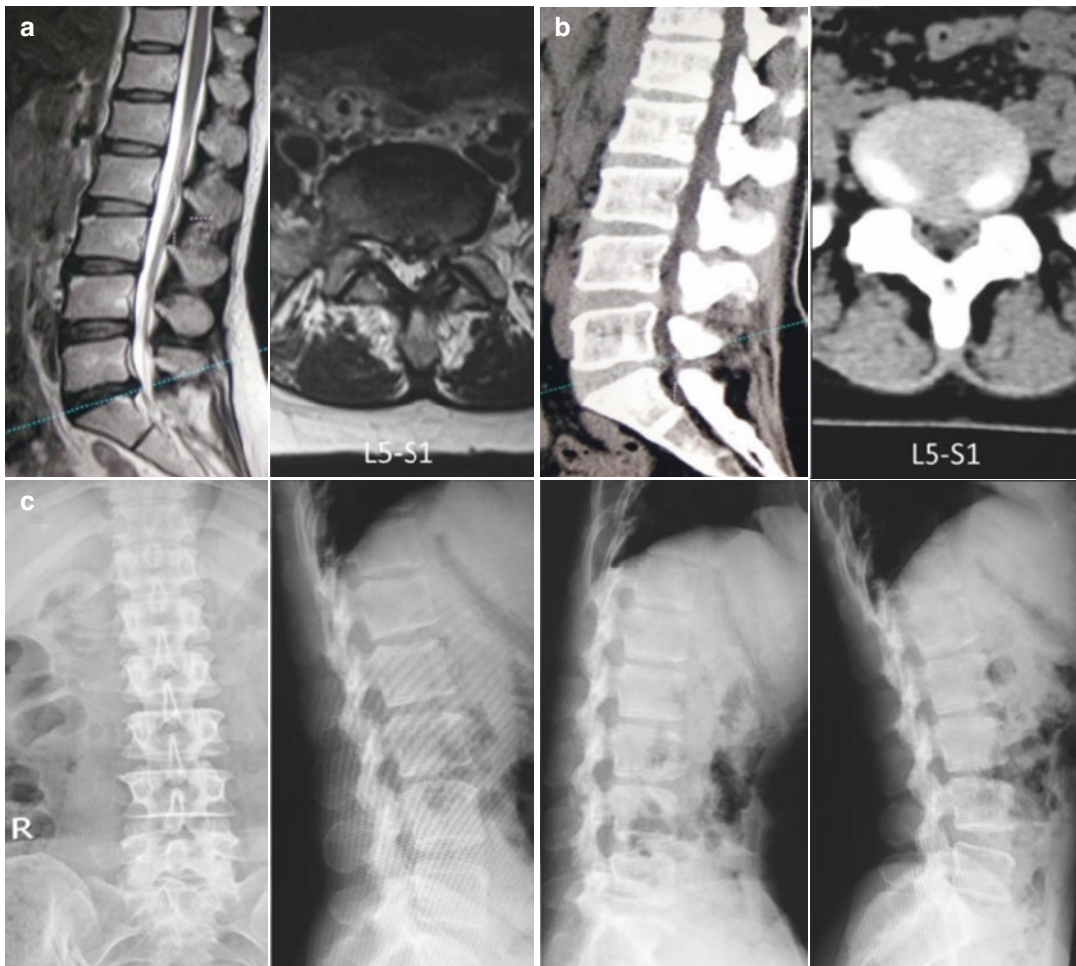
(a) and (b) Preoperative MRI and CT scan indicated L5/S1 foramininal stenosis and disc herniation on the left side. (c) Preoperative X-ray showed no instability at L5-S1 level
